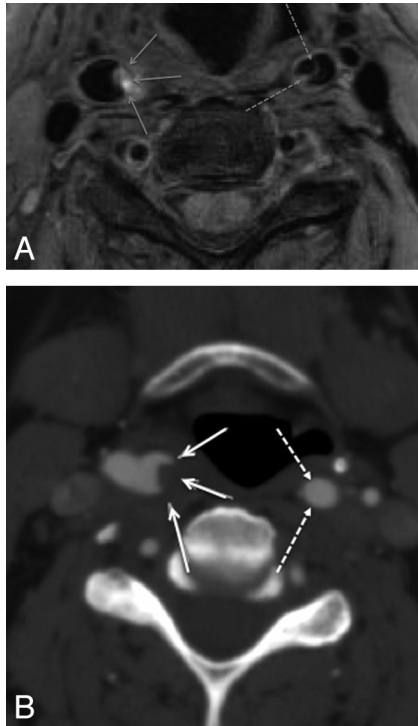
BBL (A) performed 1 day subsequent to CTA (B) demonstrates thrombus within the lumen of the right internal carotid artery (continuous arrows) but also a dissection flap in the left internal carotid artery not appreciated on CTA.
